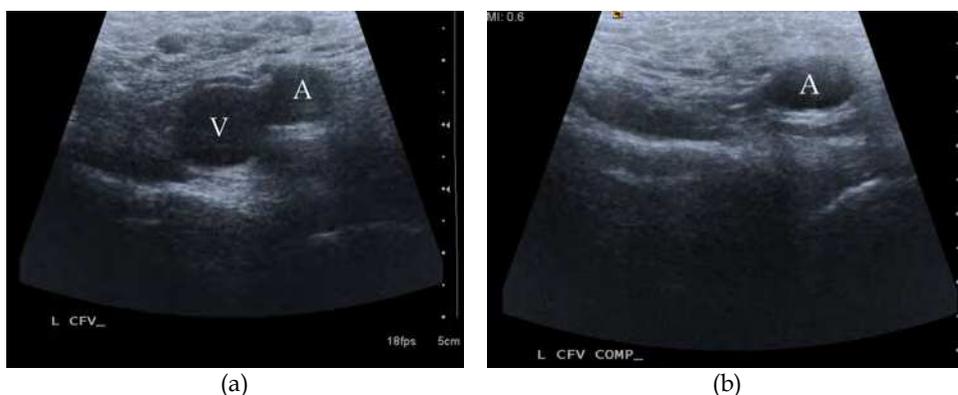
(a) Transverse ultrasound of a normal left common femoral vein (V) and common femoral artery (A). (b) Transducer compression obliterates the vein, leaving the accompanying artery unaffected (A).
